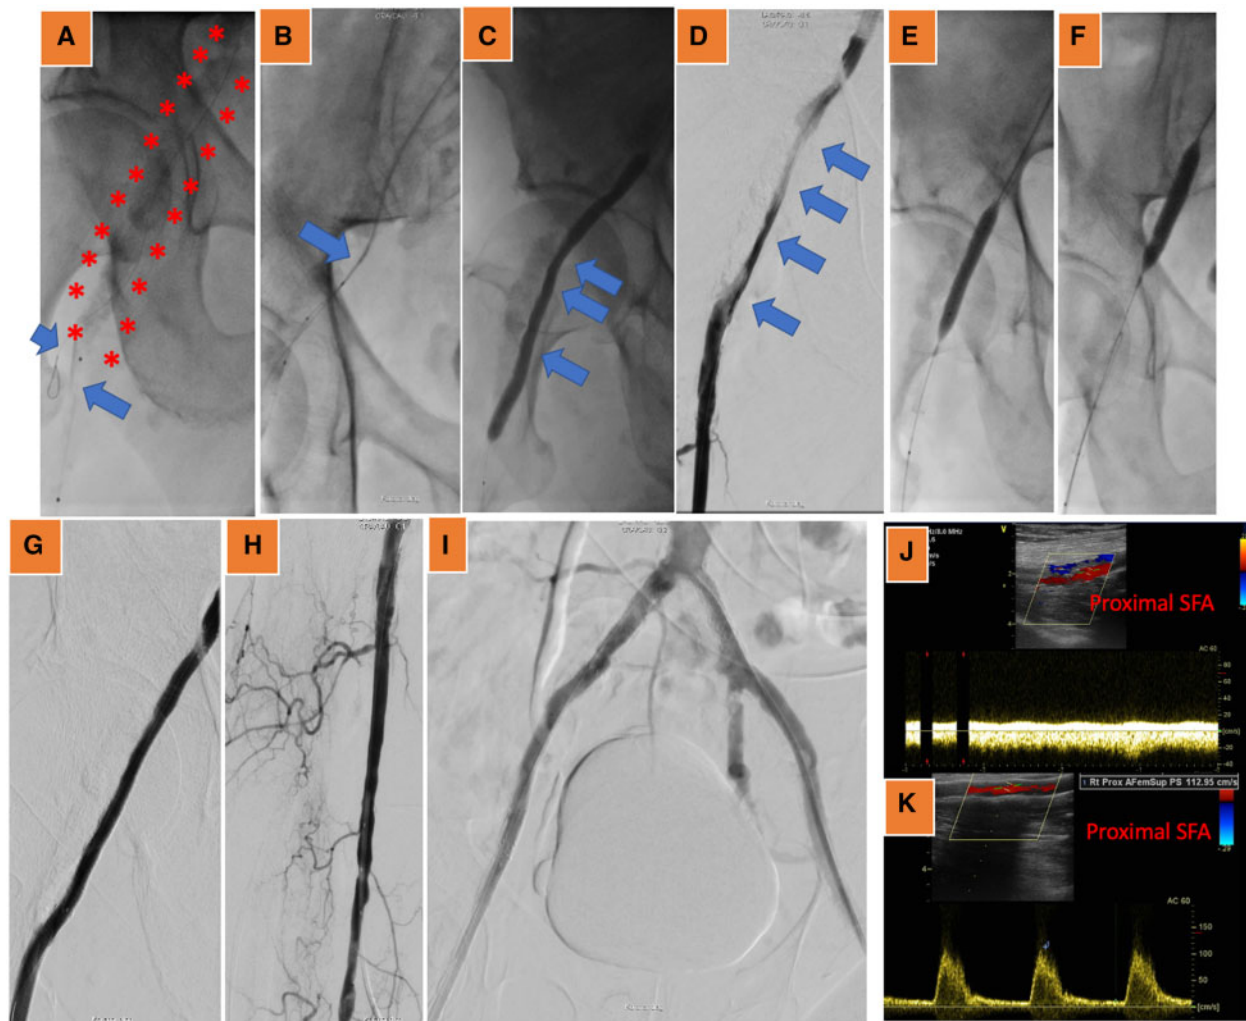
After combined antegrade and retrograde wire access to the right occlusion (blue arrows in A, red asterisks showing the extreme bilateral calcification of the right external iliac and common femoral artery, magnified in B), wire externalization was performed at the level of the right external iliac (blue arrow in C). Pre-dilatation showed inadequate balloon expansion (blue arrows in D) and digital subtraction angiography confirmed massive lesion recoil (E). Therefore, Viabahn self-expanding coated stents were implanted, which were subsequently aggressively dilated using high-pressure balloons (F, G) and were then relined using Supera™ self-expanding stents, according to the 'pave-and-crack' technique. A good bilateral final angiographic result with adequate expansion of the prosthesis and stents and good outflow of the superficial femoral artery can be appreciated in (H, I). Duplex sonography showed markedly improved flow in the right superficial femoral artery, comparing duplex findings before (J) and after endovascular treatment (K).
